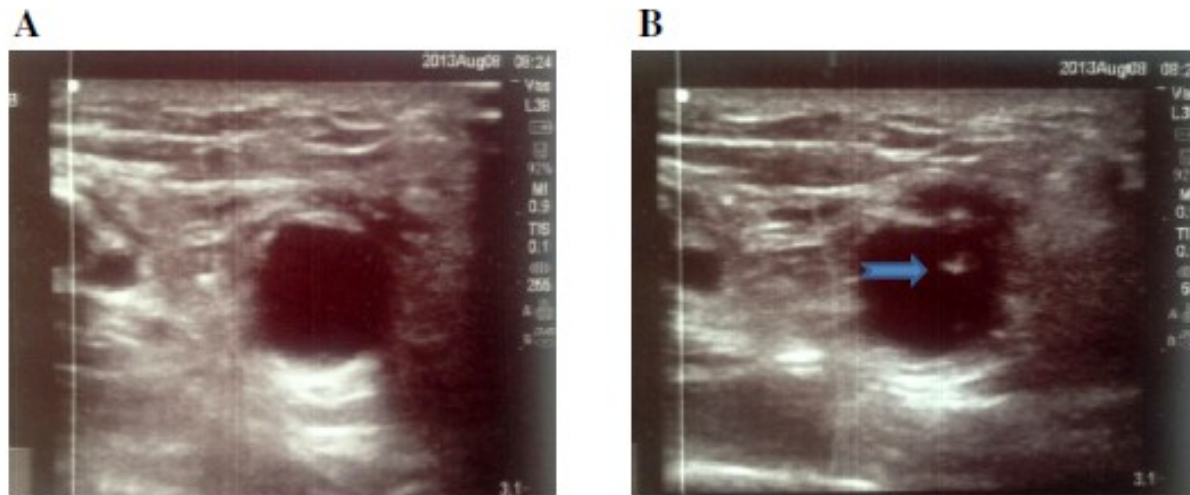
(A) Ultrasound image before cannulation showing venous tract of AVF which is 1 cm deep. (B) Ultrasound image after cannulation with needle tip in vein without any hematoma.
